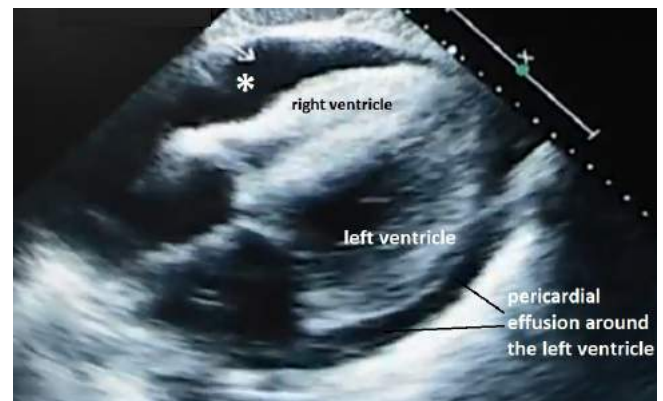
Echocardiogram, showing pericardial effusion-induced right ventricular collapse and 1-cm effusion around the left ventricle (arrows and asterisk)
